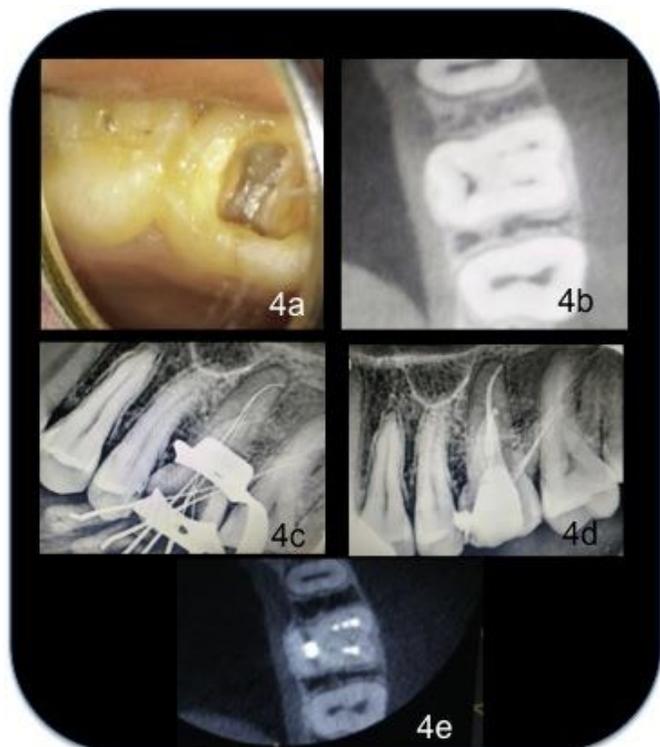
4a. Clinical image showing 6 canal orifices, 4b.CBCT image, 4c. working length determination, 4d. Post-obturation radiograph, 4e. Post obturation CBCT image
